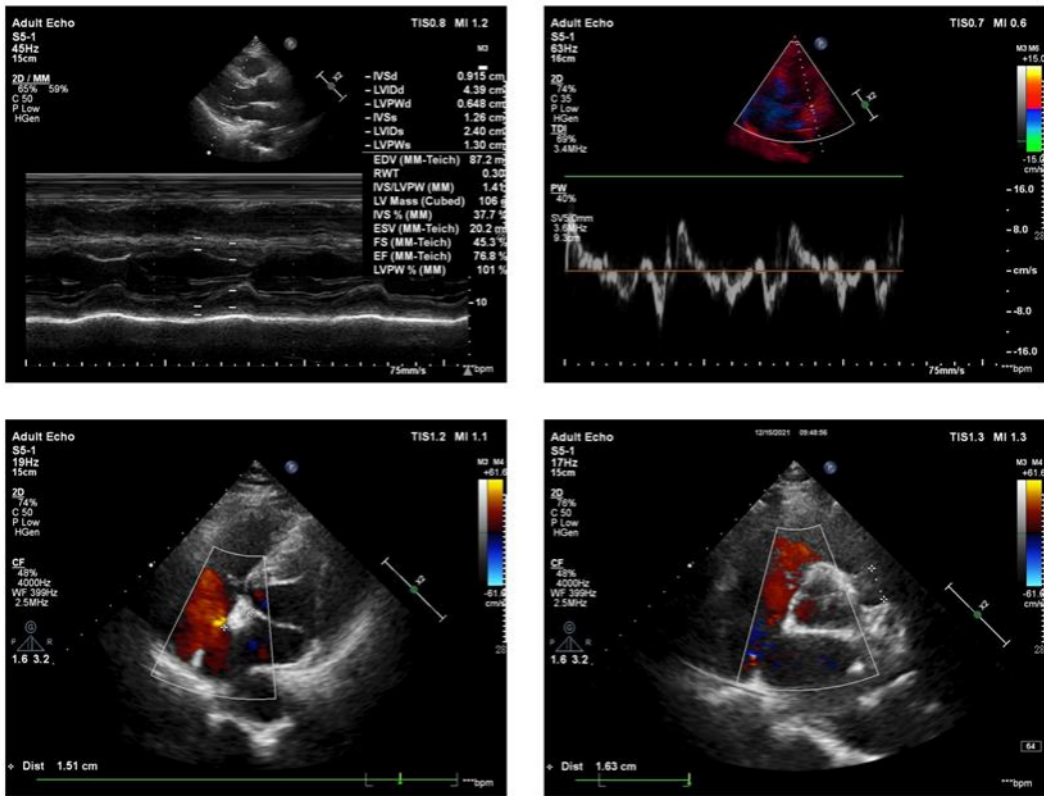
Bedside echocardiography after operation suggested no residual shunt.
